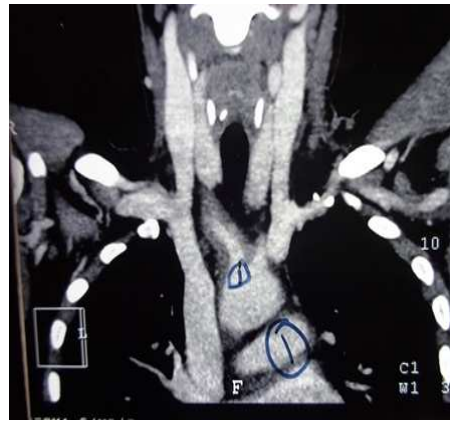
CT Aortography Showing Near Total Occlusions at Multiple Sites on Right Side as Described in Text
